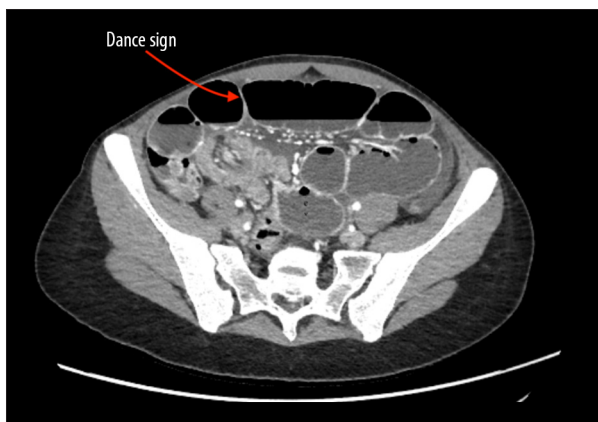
Initial computed tomography scan. Distention is noted up to the height of the right iliac fossa where a small bowel in small bowel invagination is visualized. The intestinal wall remains vascularized with a notable amount of pelvic ascites.
